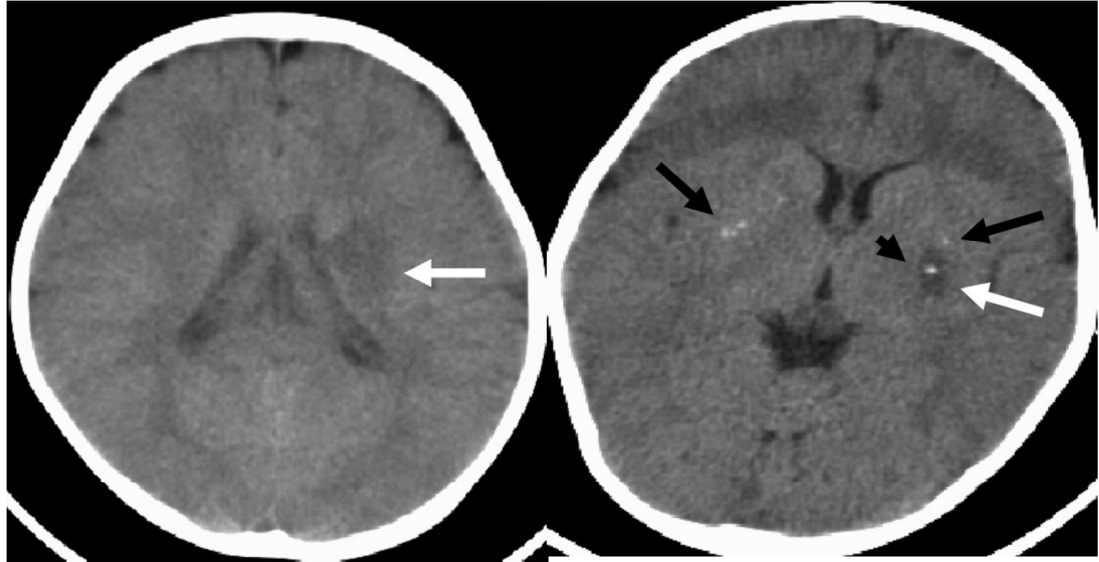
Visualization of the lenticulostriate arteries on CT
